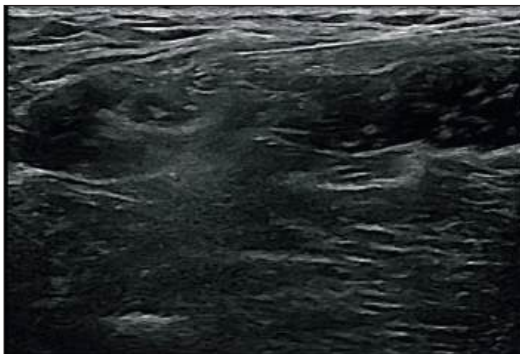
Sonographic view of lateral femoral cutaneous nerve and radiofrequency needle.
